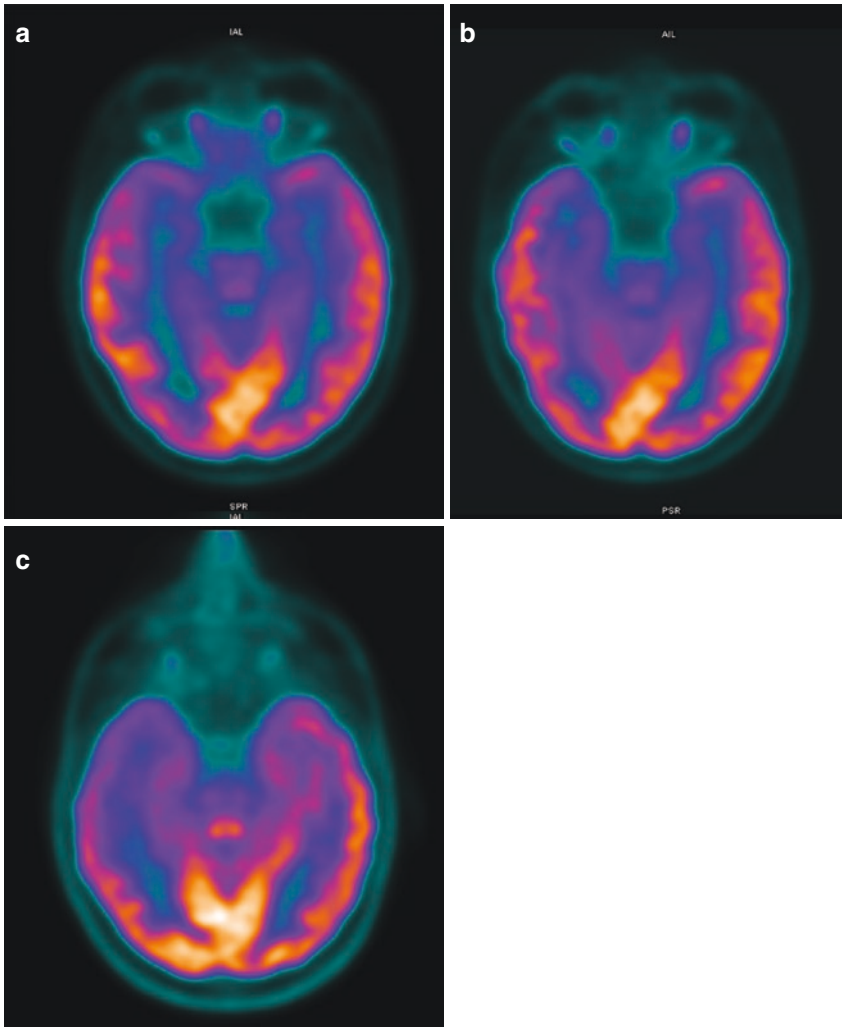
An example of two ^{18}F -FDG brain PET/CT patient images with indication of epilepsy. The images show how misalignment can contribute to image artefacts. (a) Patient 1: A ^{18}F -FDG brain PET/CT epilepsy scan with normal uptake that has been correctly aligned. (b) Patient 1: The same patient with the images rotated in the coronal plane giving an impression of asymmetry in uptake and the potential to be incorrectly reported as the right temporal lobe epilepsy. (c) Patient 2: A correctly aligned patient with right temporal lobe epilepsy for comparison
